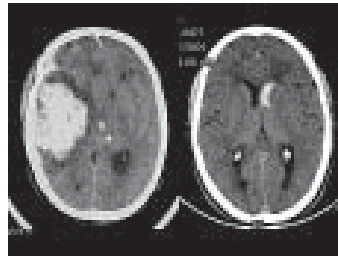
CT Brain showing Intracerebral Hematoma (left panel) seen as a large hyperdense area at right side, which primarily expands between relatively normal neurons. The CT at right panel shows Intraventricular Hemorrhage, which is seen as hyperdense material within the frontal horn of lateral ventricle, attributable to rotationally induced tearing of subependymal veins.
